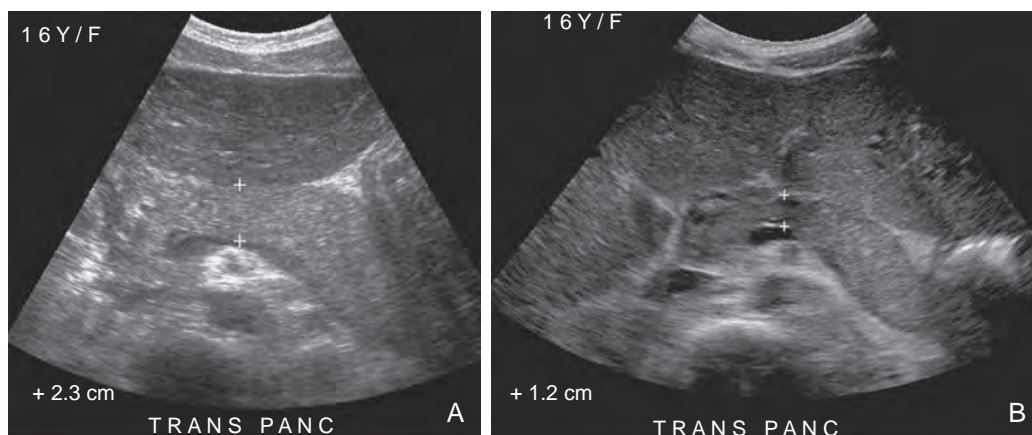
Acute pancreatitis. A. The transverse sonographic image through the pancreas shows a diffusely enlarged pancreas that is echogenic compared with the liver in a 17-year-old girl with a history of thrombotic thrombocytopenic purpura. B. Follow-up ultrasound of the same patient 2 weeks later demonstrates interval decrease in the size of the pancreas, with decreased echogenicity compared with the liver.
